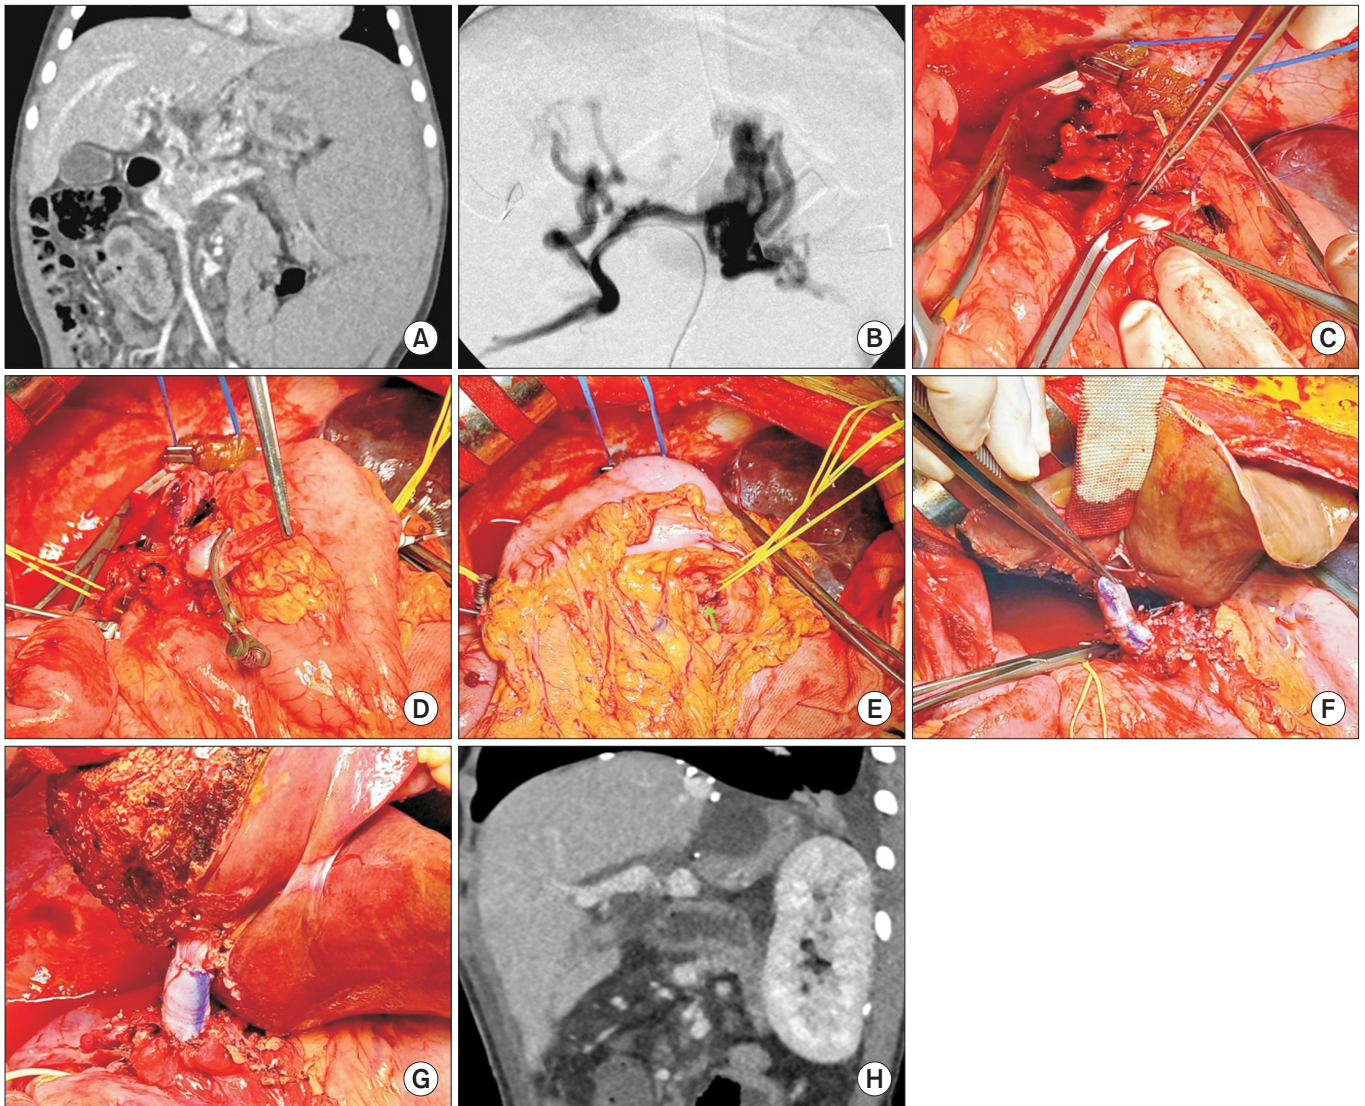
Image summary of living donor liver transplantation case 5. (A) Pretransplant computed tomography (CT) showed congenital absence of the portal vein with portal hypertension and splenomegaly. (B) The first intraoperative cine-portogram demonstrated that most splanchnic blood drained into the splenorenal shunt. (C) The largest collateral vein adjacent to the common bile duct was side-clamped and opened. (D) An iliac vein homograft was anastomosed to this collateral vein in an end-to-side fashion. (E) The splenic vein (arrow), just distal to the inferior mesenteric vein insertion site, was ligated. (F) The portal vein conduit was connected to the graft portal vein after distance matching. (G) The interposed portal vein conduit was streamlined without redundancy. (H) Posttransplant CT obtained 5 days later showed a well-visualized portal vein conduit. Reproduced from Namgoong et al. *Ann Liver Transplant* 2022;2:69–77. [10]
